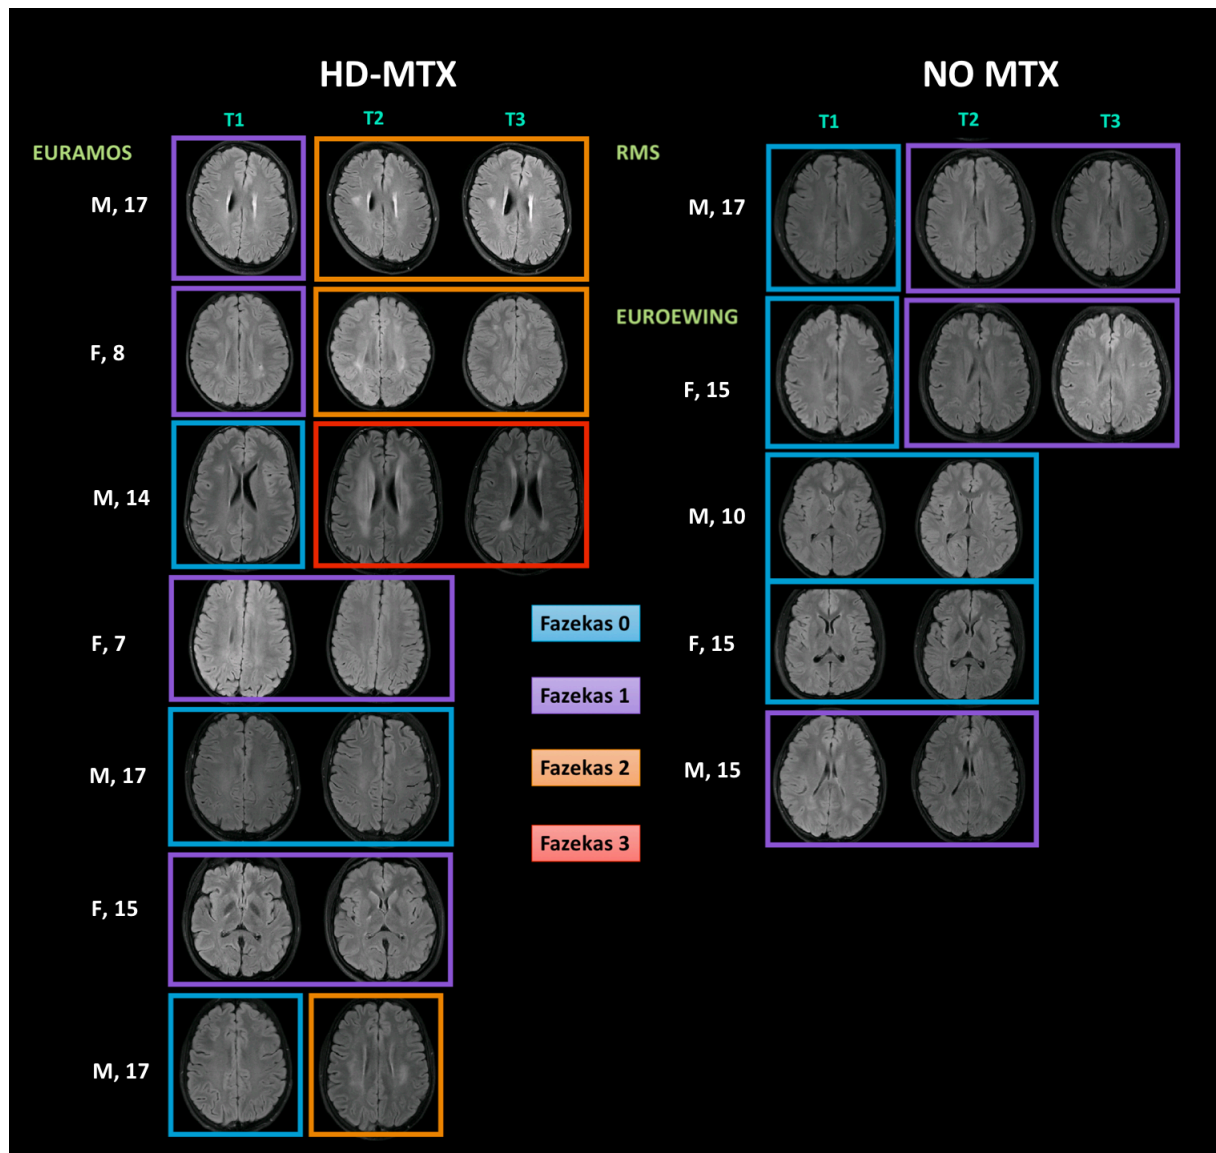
Fazekas rated FLAIR MRI scans for all patients at T1, T2, T3.
